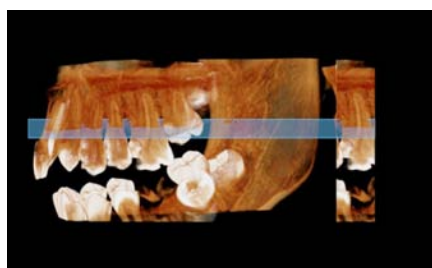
(a, b, c, d, e, f): Pre-Operative CBCT estimation starting from alveolar crest level, and every 2mm apically till 10mm, and alveolar bone bucco-palatal change in cross sectional images
